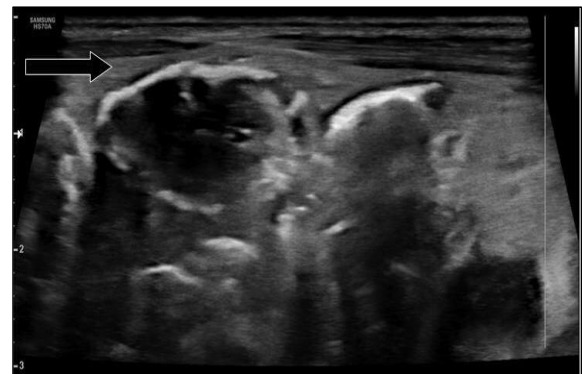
Another high frequency sonographic image calcified lesion with posterior acoustic shadowing.
